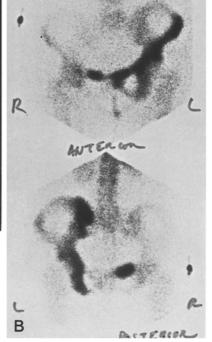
False-positive scan resulting from Paget disease involving left hemipelvis. A Radiograph reveals cortical thickening and increased breadth of entire left hemipelvis. B Scan discloses corresponding characteristically intense and extensive radionuclide activity
